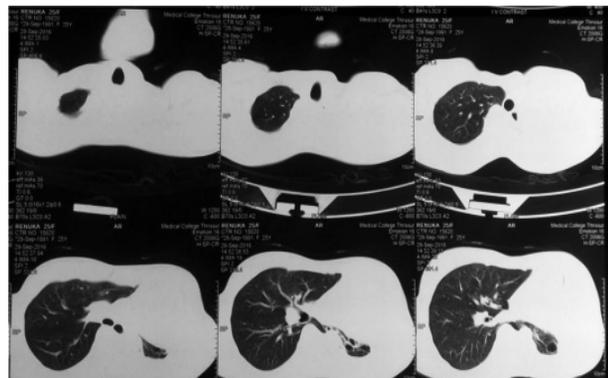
CT thorax lung window- posterior herniation of Rt. Lung
